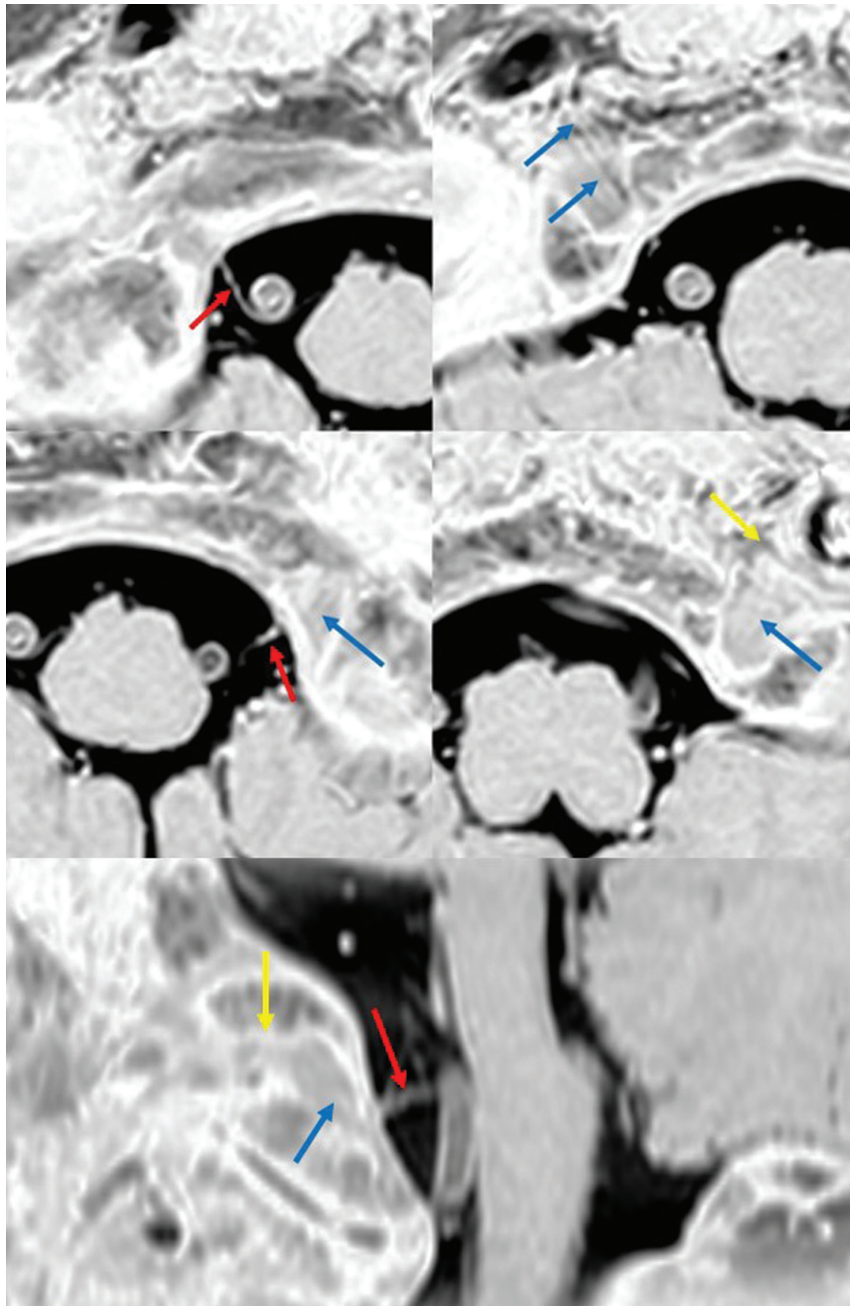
High-resolution MRI of the bilateral hypoglossal nerves. Upper panel: The right hypoglossal nerve, the cisternal segment (red arrow), and the basicranial segment are visible in the hypoglossal canal (blue arrow); isointense nerve surrounded by the hypointense cerebrospinal fluid.⁹⁾ The right hypoglossal nerve is intact the whole way through the hypoglossal canal. Mid panel: The left hypoglossal nerve, the cisternal segment (red arrow), and the basicranial segment are visible in the hypoglossal canal (blue arrow). The proximal basicranial segment was intact, while the continuity in the distal segment was lost in the external orifice of the canal (yellow arrow). Lower panel: Oblique sagittal image of the left hypoglossal nerve shows the cisternal segment (red arrow), and the basicranial segment are visible in the hypoglossal canal (blue arrow), but the external orifice of hypoglossal canal is obstructed by osteophyte (yellow arrow). MRI: magnetic resonance imaging.
